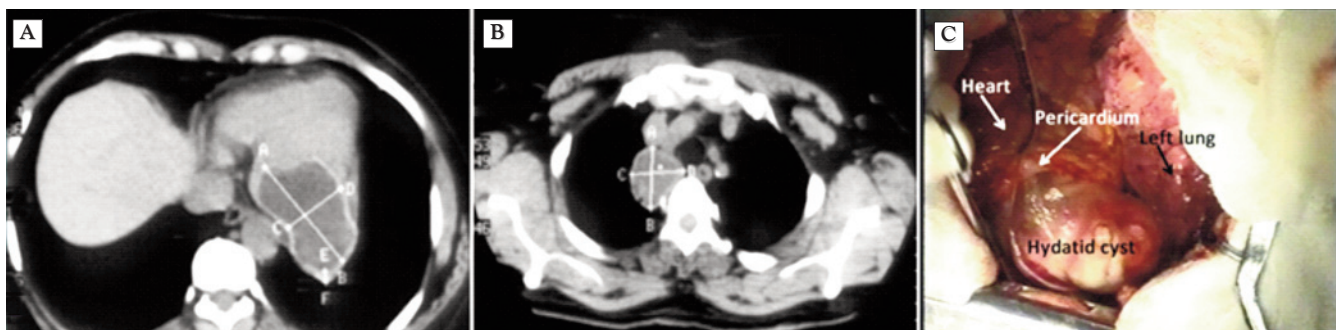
(A) CT – hydatid cyst localized at left myocardium level; (B) CT – hydatid cyst of left lung (anterior segment, left superior lobe); (C) Intraoperative aspect – hydatid cyst localized at left myocardium level
